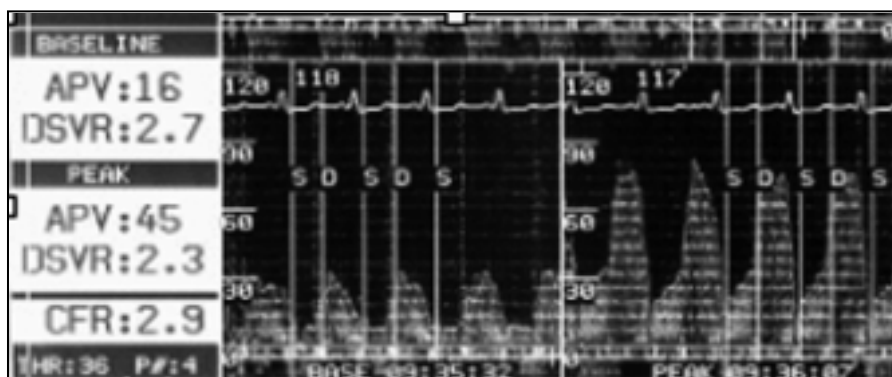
An example of a normal Doppler wire-derived coronary flow reserve. The left panel represents the resting Doppler velocity, and the right panel shows the peak Doppler velocity. APV, average peak velocity; DSVR, diastolic systolic velocity ratio; S, systole; D, diastole.
